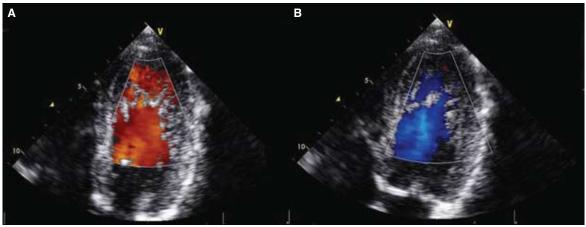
Color flow Doppler images of the left ventricle (A) at systole and (B) at diastole showing deep trabeculae and intratrabecular recesses with blood flow inside.
